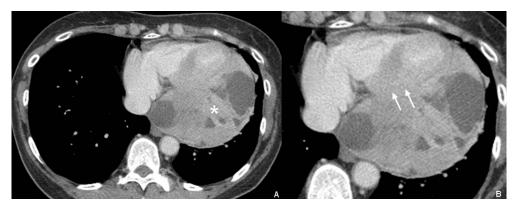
(A) Contrast-enhanced axial computed tomographic scan, demonstrating a large mixed solid-cystic pericardial mass. The solid component shows heterogeneous enhancement (asterisk). (B) Contrast-enhanced axial computed tomographic scan (zoomedin image) demonstrating no distinction in the fat plane separating the mass from the myocardium at the inferoposterior aspect of the left ventricle (white arrows).
